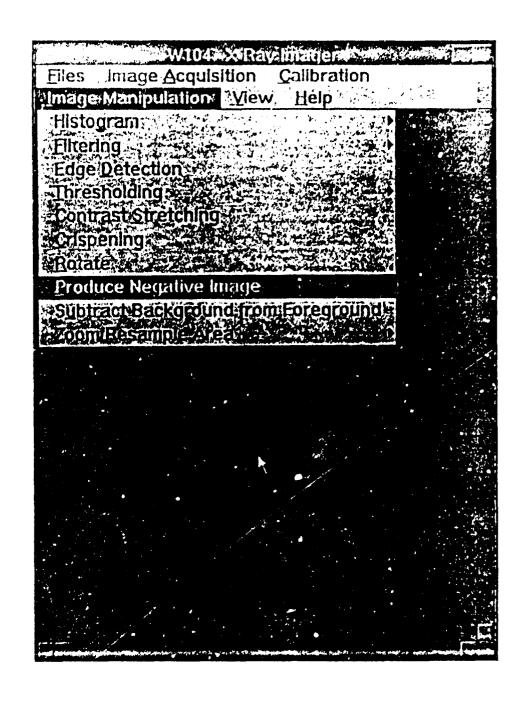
An example of XRAYWIN user interface.
